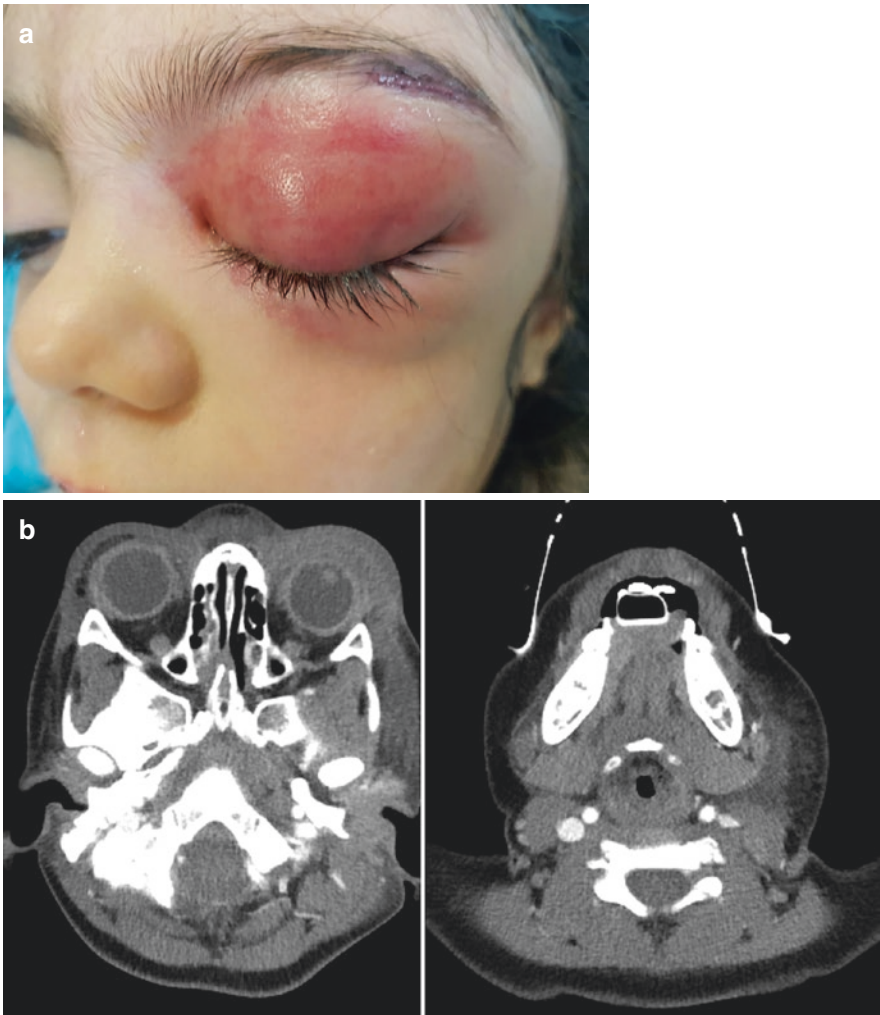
Day 2. (a) Palpation called for abscess drainage. (b) CT scan demonstrating extensive soft tissue swelling of the left face and neck. (c) In the operating room. Notice the rose-purple color of the left eyelids and the involvement of the right eyelids. (d) Debridement of ischemic tissue
